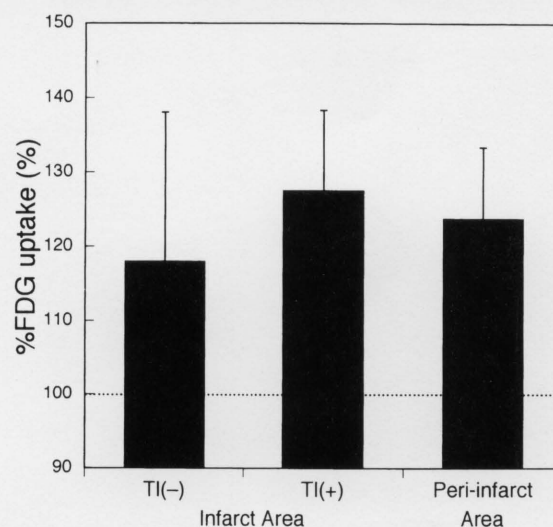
Normalized %FDG uptake of myocardium during the sub-acute phase in patients with successful revascularization for acute myocardial infarction. TI (+): area showing TI-uptake in infarct area; TI (-): area showing defects in TI images in infarct area.
